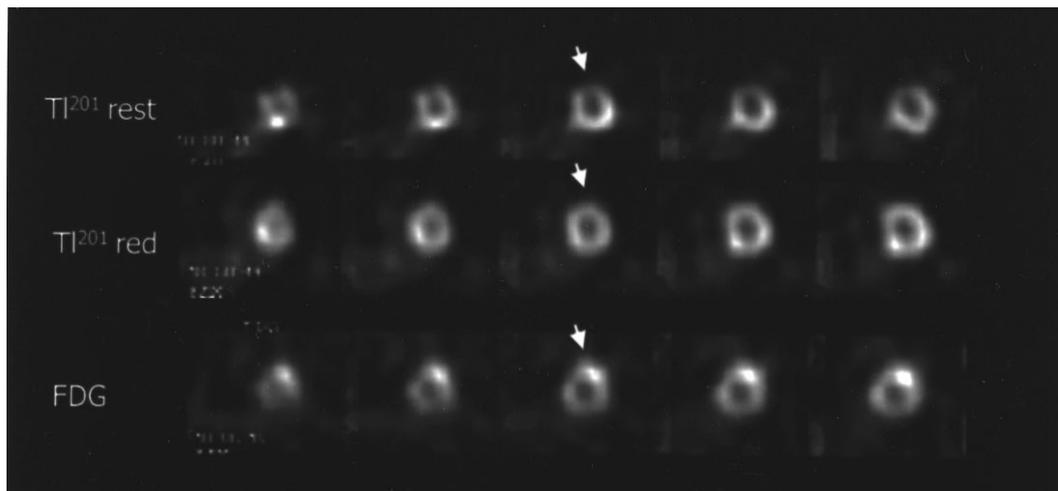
Fifty-year-old female with a recent anterior MI (90% proximal LAD stenosis); treated with PTCA and stent ten days post MI. FDG was performed at day 11 post MI. ²⁰¹Tl Rest: anteroapical perfusion defect at rest (*first row*); ²⁰¹Tl Red: the defect showed important improvement in the redistribution images (*second row*); FDG: significant hypermetabolism in anteroapical segment (*third row*). Anterior and apical wall motion recovery was observed in the follow-up echocardiogram at 3 months.
